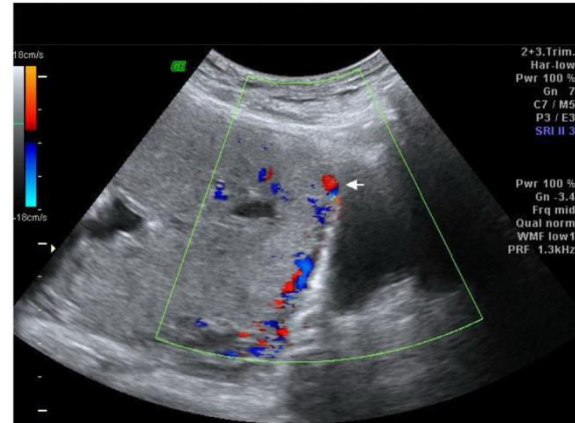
Placenta percreta in 26 year old pregnant female patient at 30 weeks of gestation came to the obstetric department by vaginal bleeding with history of previous 2 C.S. Color Doppler showing the placenta is extending to the serosal surface of the bladder without any intervening myometrium. By color Doppler, suspected crossing vasculature from uterine serosa to bladder. Patient was found to have placenta increta.US had displayed false positive diagnosis of invasion in 2 cases, true negative in 7 cases and false negative in 3 cases.
